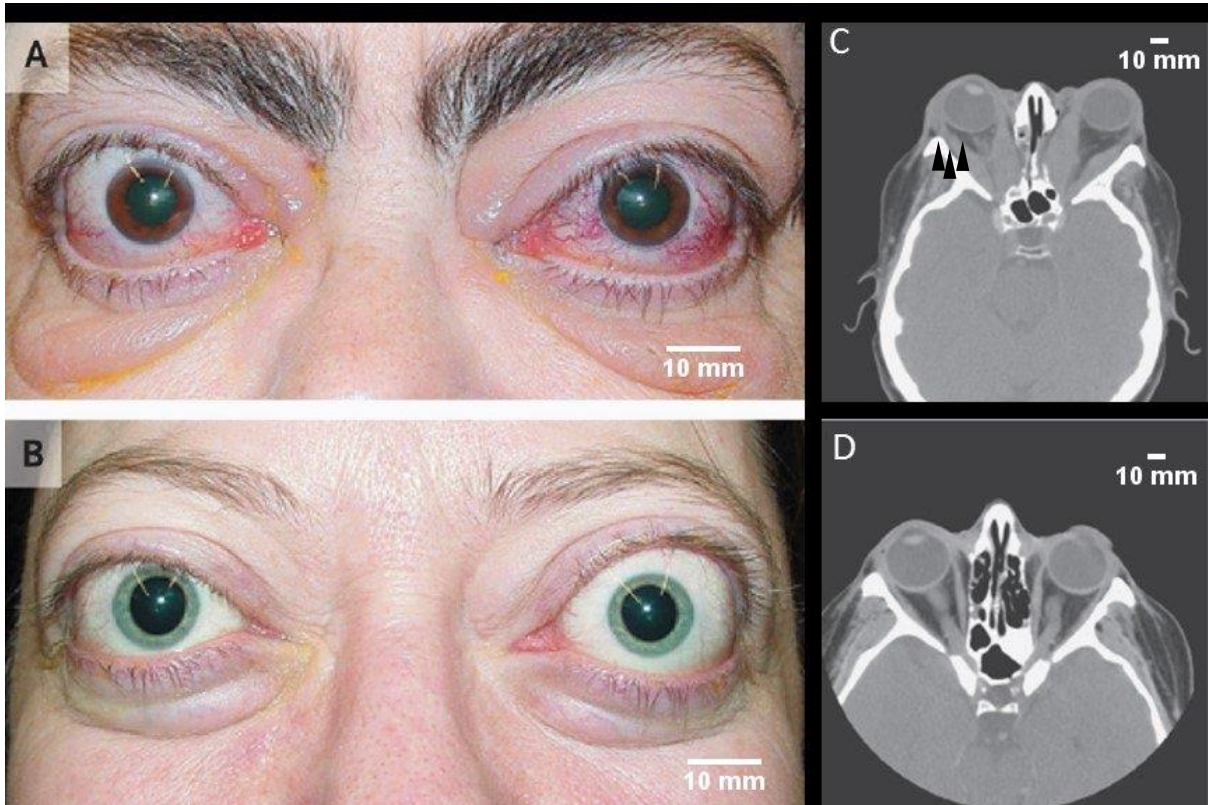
Patients with TED and computed tomographic scan of a TED patients and a normal subject. A&B) Women with excess proptosis, moderate eyelid edema, and erythema of the periorbital tissues and conjunctivae, as well as eyelid retraction. Proptosis and eyelid edema are more prominent on panel B (left) than panel A (left). C) Computed tomographic scan showing the cross section of the head of a TED patient at eye level. Displaying generalised enlargement of the extraocular muscles with distinct bilateral proptosis resembling the left panels. Excessive orbital tissues compressing the optic nerve can be seen (black arrows). D) Normal orbits are shown for comparison (*Bahn, 2010*).
